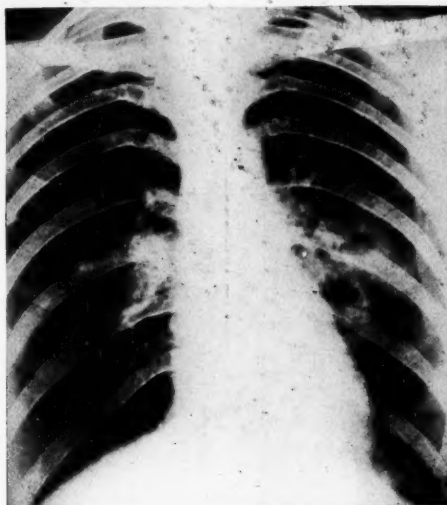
on 25.5.37. Smooth infiltration spreading from the left hilum in the centre of which is a cavity. In the actual X-ray a faint mottling can also be seen on the right side round the calcified patch in the third interspace
